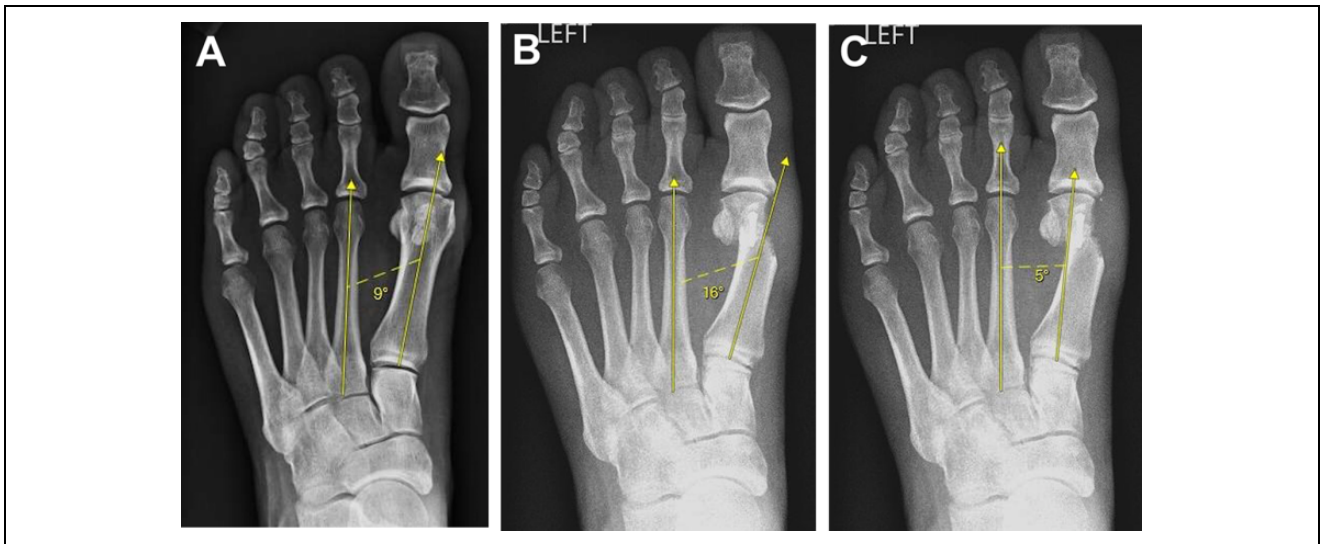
Postoperative anteroposterior radiographs of the foot following distal chevron osteotomy for symptomatic hallux valgus correction. (B) The anatomic first–second intermetatarsal angle (a1-2IMA) was defined as the difference between the diaphyseal axis of the first and second metatarsals. (C) The mechanical first–second intermetatarsal angle (m1-2IMA) was defined as the difference between the mechanical first and second metatarsal axes, drawn from the center of the metatarsal head to the center of the metatarsal base. (A) This patient was noted to have an increase in the a1-2IMA of 7 degrees and a decrease in the m1-2IMA of 4 degrees from a preoperative intermetatarsal angle of 9 degrees.
